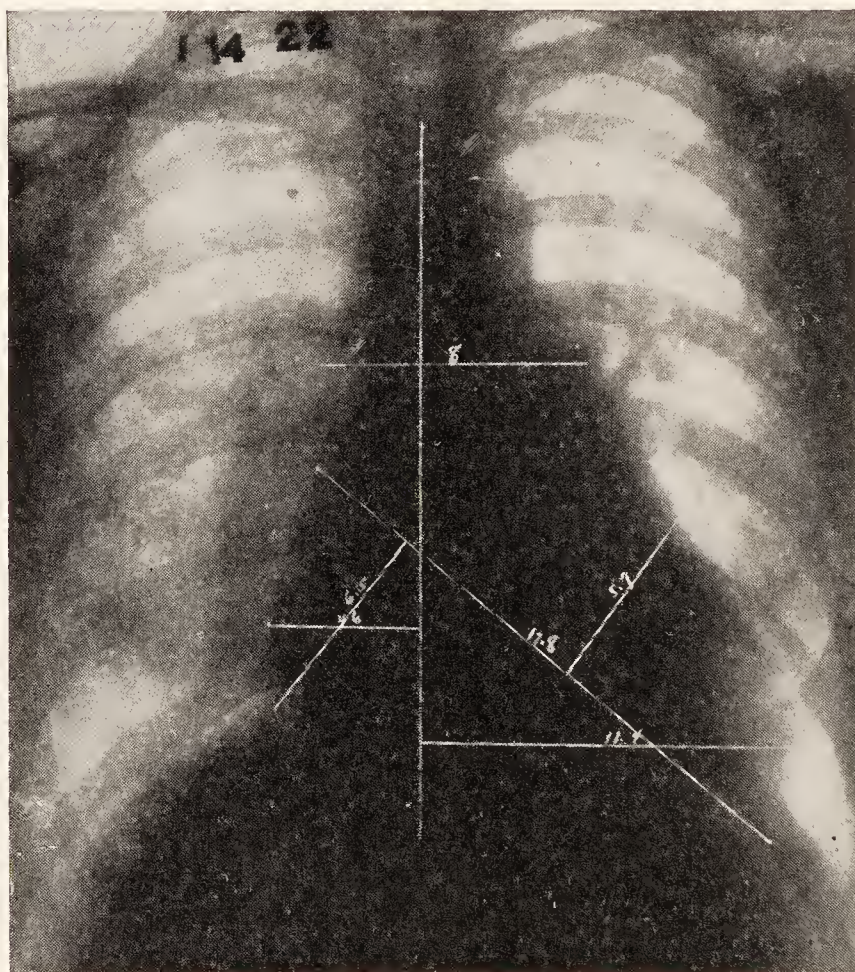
Necropsy 4292. Mitral stenosis. Mural thrombi of the auricular appendices. Embolic thrombosis of branches of the pulmonary artery. X-ray shows general enlargement of the heart shadow, the greatest prominence in the region of the auricles, particularly the left. (Roentgenological Department, Massachusetts General Hospital.)
